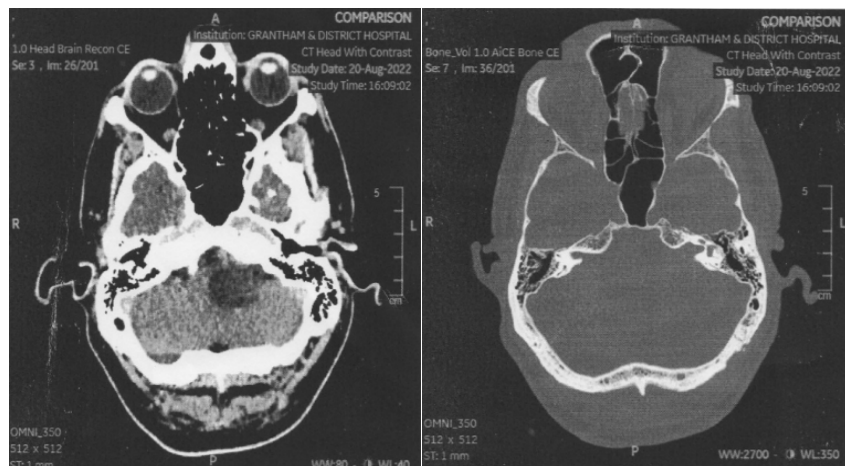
CT head of the patient after surgical removal of the tumor.
